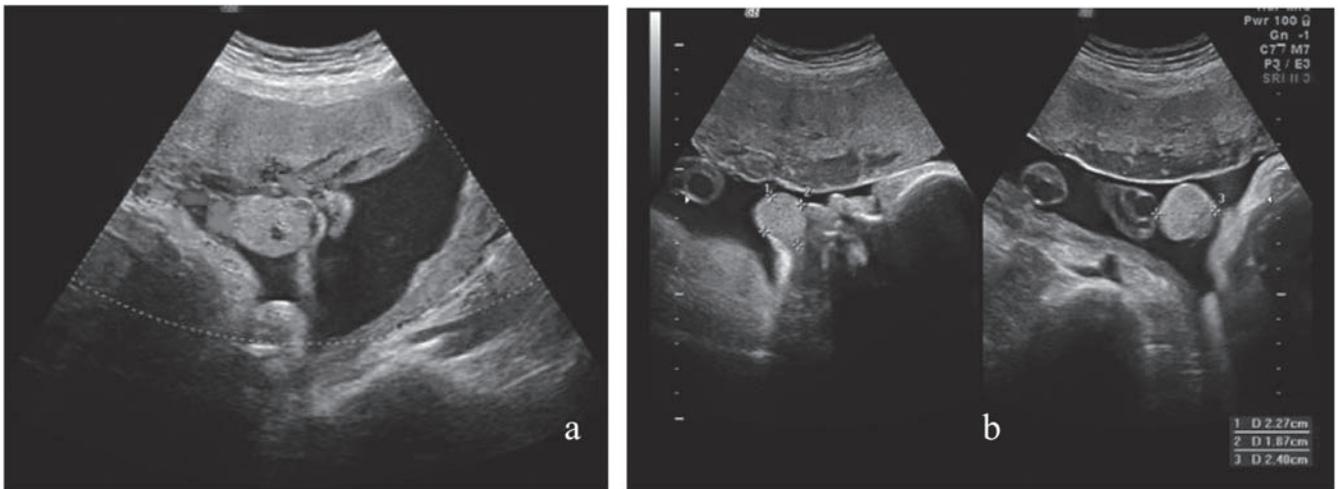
(a) An ultrasound scan performed in the 32nd week of gestation showed a well-defined, smooth, round and hyperechoic mass with marked blood flow in the oral cavity. The mass did not interfere with the swallowing, or the foetal tongue's mobility. (b) Size of the mass 2.3 x 1.9 x 2.4 cm.
